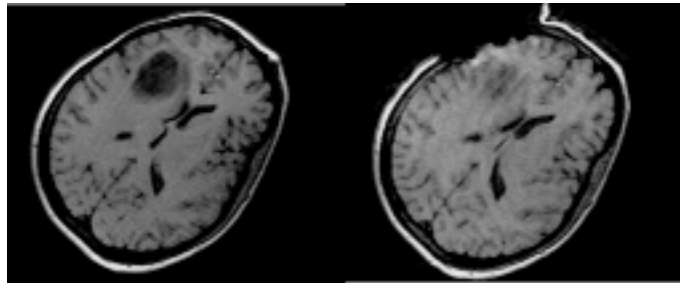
MRI image of a patient before and after the start of surgery.
